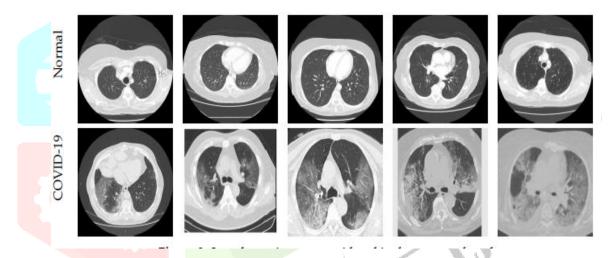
CT Scan Images of Normal or Covid-19 Patients
